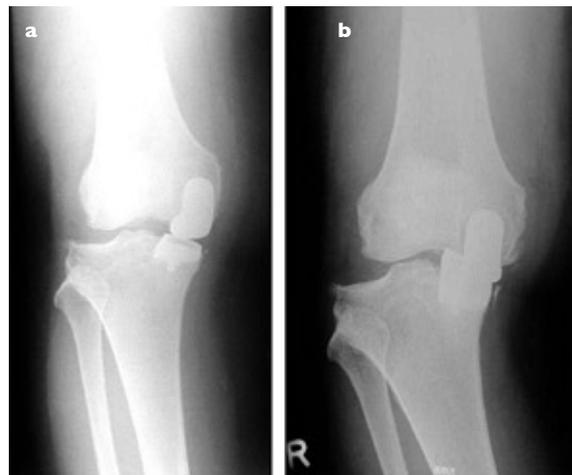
Postoperative AP radiographs of UKA show (a) edge loading due to malalignment of prosthesis compared with (b) a good alignment in another patient.
